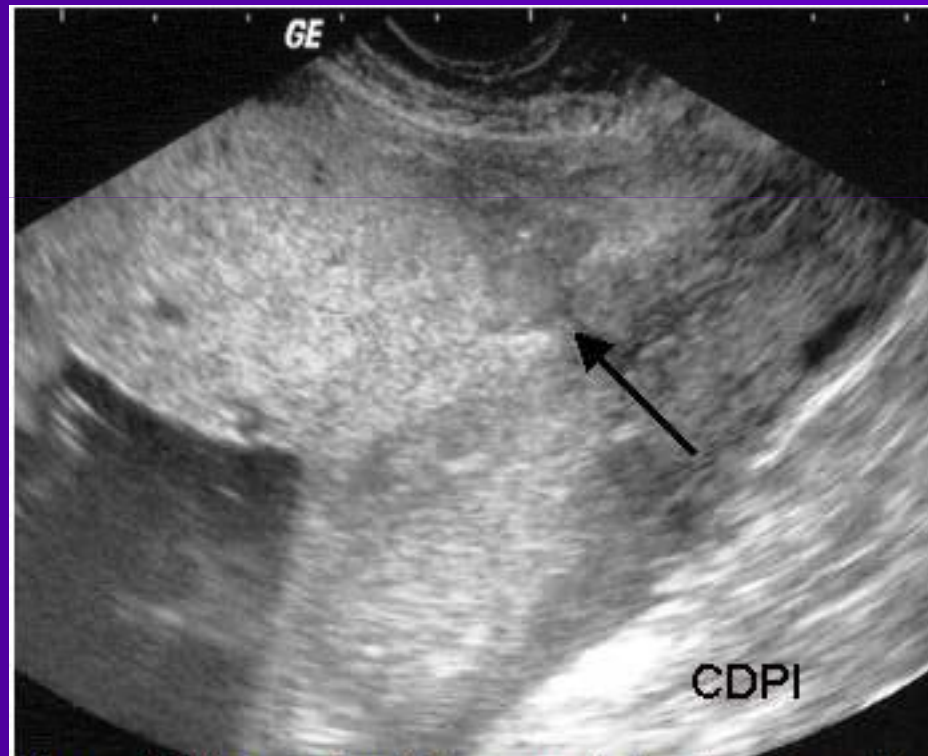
Ultrasound with transvaginal probe shows the placenta previa in central over the internal os (arrow).
